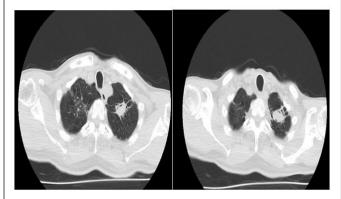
Computed tomography of chest axial view.
